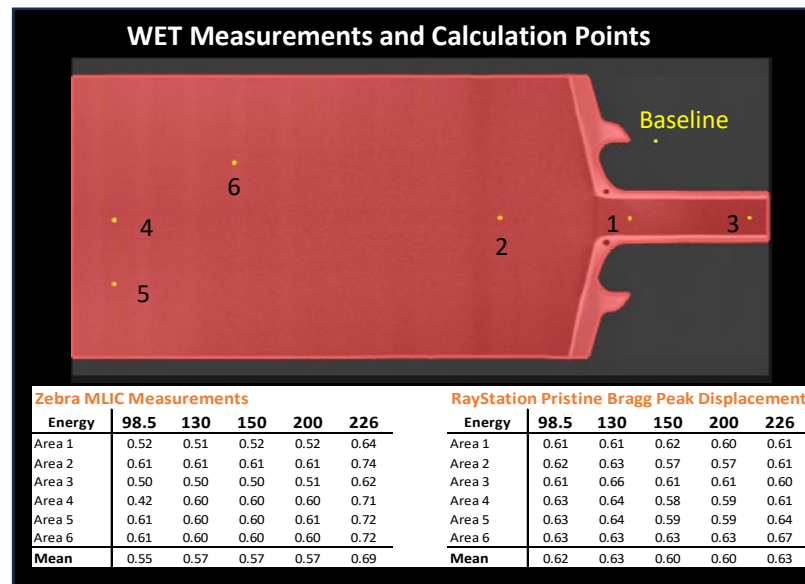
Coronal CT Image showing the measurement locations on the Pronumbra Board (Top) and corresponding experimental and Monte Carlo WET results for multiple energies (Bottom).
